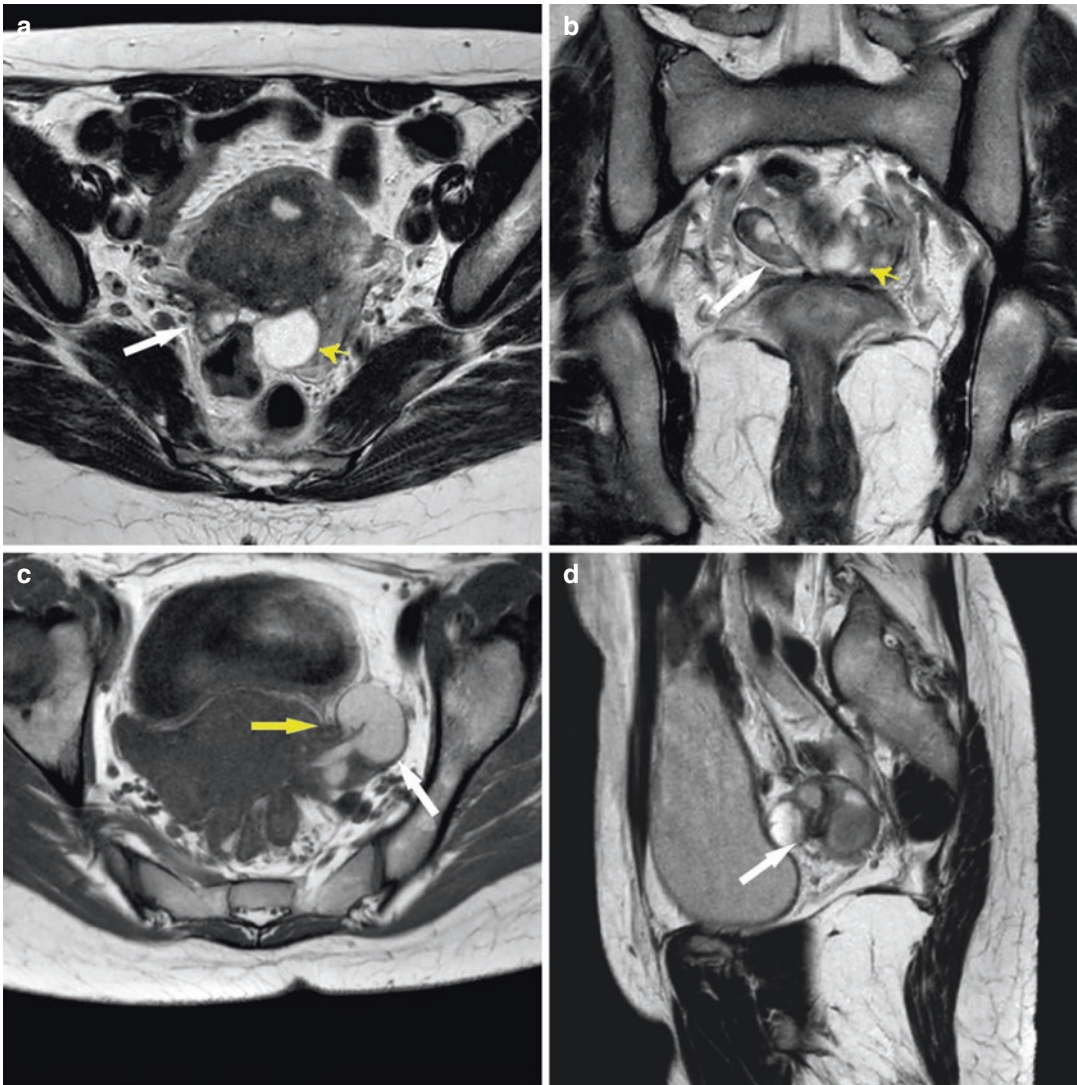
Adhesions.* (a, b) Endometriosis in a 37-year-old woman; axial T1-weighted (a) and coronal T2-weighted (b) MR images show low signal stranding between the ovaries and between ovaries and uterus. The inter-ovarian adhesions cause the closing up of right adnexa (white arrow) and left adnexa (yellow arrow) with tethering to the uterus. (c, d) Haematosalpinx in a 36 year-old woman.
